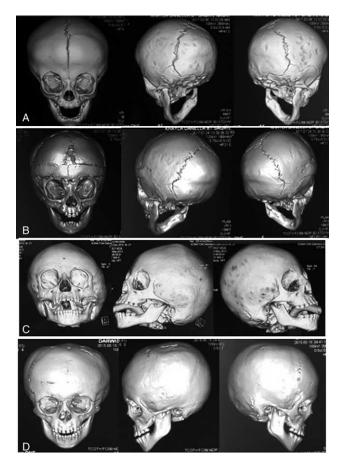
(A) 3D CT imaging preoperative showed significant of copper beaten sign. (B) 3D CT imaging showed incomplete resolution of copper beaten sign 3 months post-surgery. (C) 3D CT imaging preoperative showed significant of copper beaten sign, (D) 3D CT imaging showed complete resolution of copper beaten sign 3 years post-surgery.
